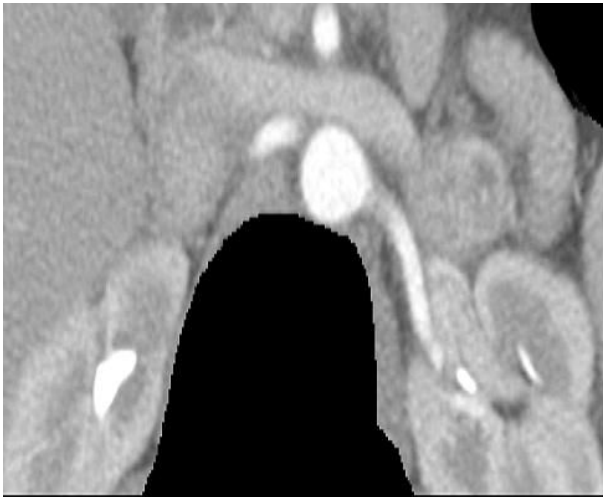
A multislice CT angiogram of the left renal artery. Left renal artery and its branches appear normal. A left adrenal tumor is observed.
